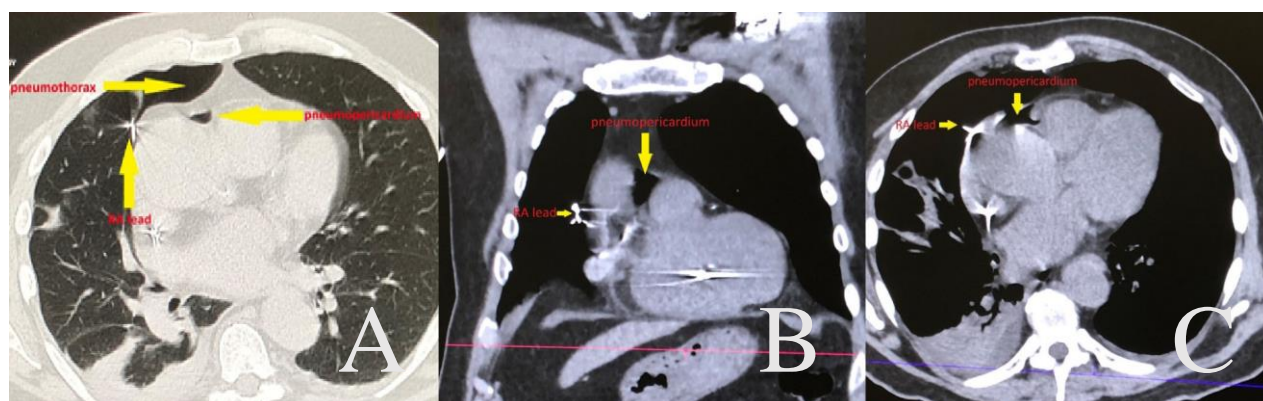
Chest CT scan image 1 day after pacemaker implantation. A) and B) Axial CT image shows the right-sided pneumothorax, right atrial appendage perforation by atrial lead, and pneumopericardium. C) Coronal CT image showing the atrial lead perforation through the right atrial appendage, pneumopericardium.
